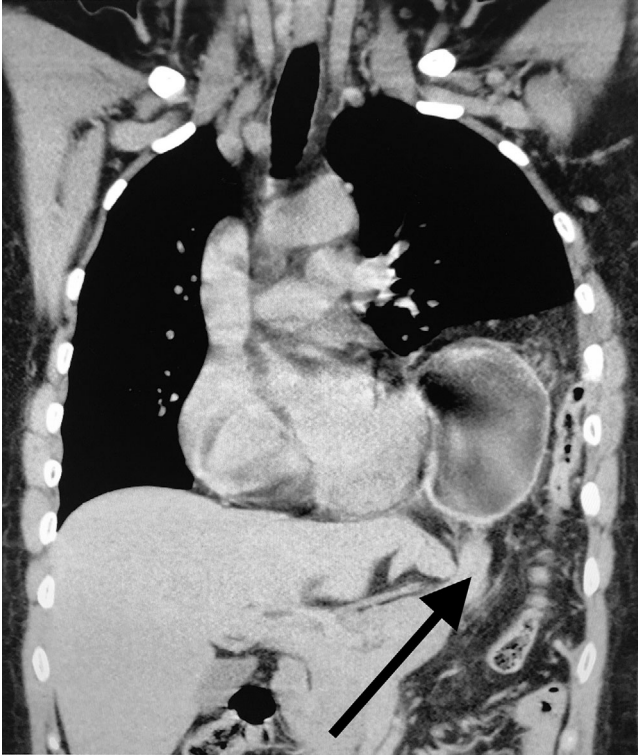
A coronal slice of a contrasted computed tomography on the day of her repeat visit demonstrating abdominal herniation into the left hemithorax through the diaphragm defect (black arrow)
